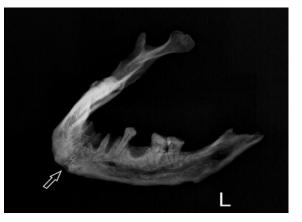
X-Ray scan of the mandible. Visible canal (white arrow) on anterior part of the mandible in the incisor region.
